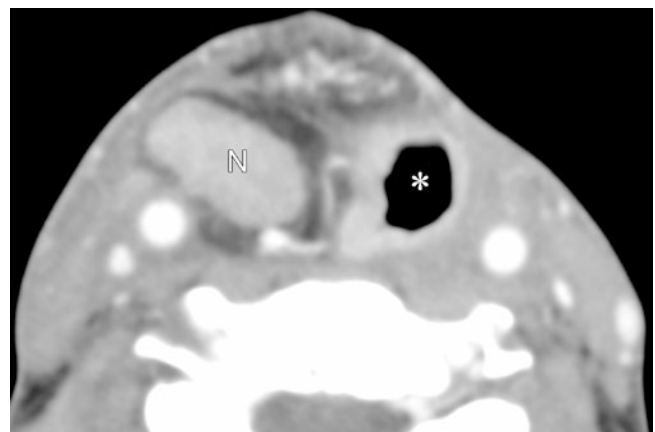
Post TPLE neopharynx. Axial contrast-enhanced CT demonstrates the neopharynx (asterisk). Secondary lymph node swelling is seen at the mesenteric lymph node of the neopharynx. This node was observed to remain the same size for over 3 years after operation
